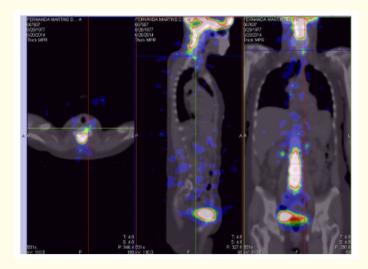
SPECT/CT localizes foci of increased uptake, suggesting cervical spine CSF leak.
